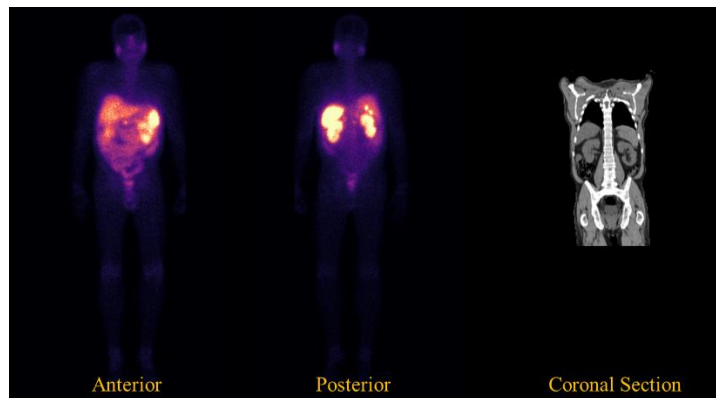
Original anterior-posterior planar WB scan and coronal section of the CT scan acquired approximately 24 h PI in the first treatment cycle of patient #1. Two saturated NETs are seen in the posterior projection. Before computing the geometric mean, pixel-by-pixel, the displayed posterior view was mirrored.
